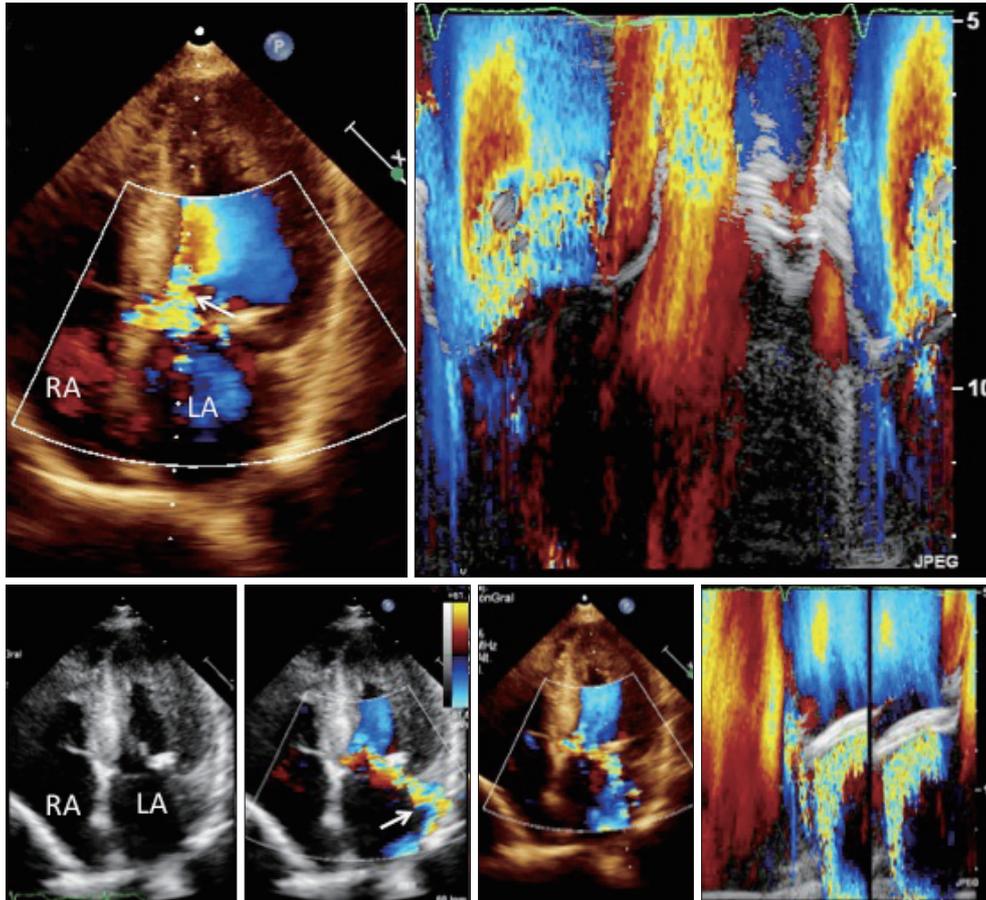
Two-dimensional echocardiography, M mode and color Doppler of an obstructive septal asymmetric hypertrophic cardiomyopathy. Mitral valve calcification and systolic anterior motion of the mitral valve is observed (white arrow). In the apical 4-chambers view, a dilated left atrium and severe mitral insufficiency is shown (white arrow). LA: left atrium, RA: right atrium.
